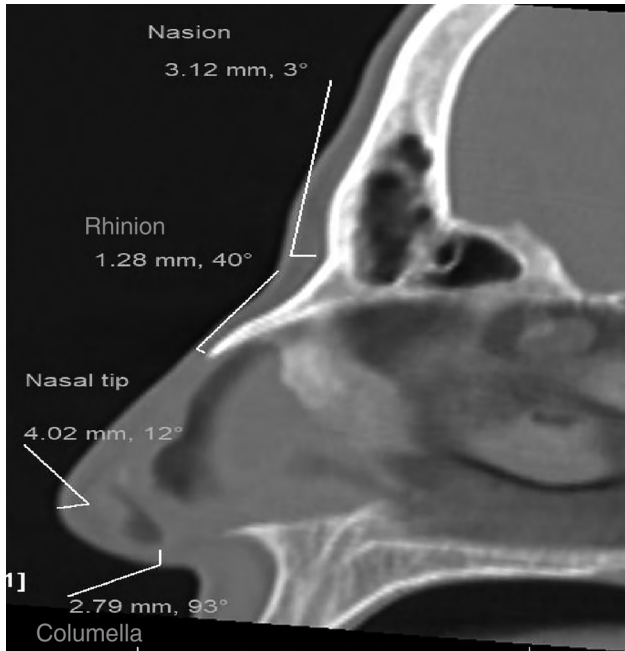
Reflects the measurement of nasal skin thickness using CT at four aesthetic points: nasion, rhinion, nasal tip, columella. The thickness was measured in millimeters.
